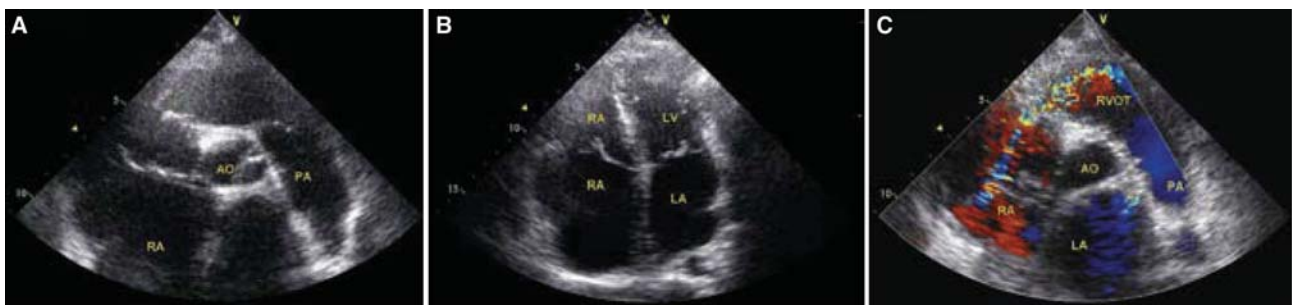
(A) Transthoracic echocardiographic short-axis images showing increased tissue density in the right ventricle and (B) significant dilatation in the right heart chambers. (C) Color Doppler image suggesting narrowness in the right ventricle due to increased tissue density.
